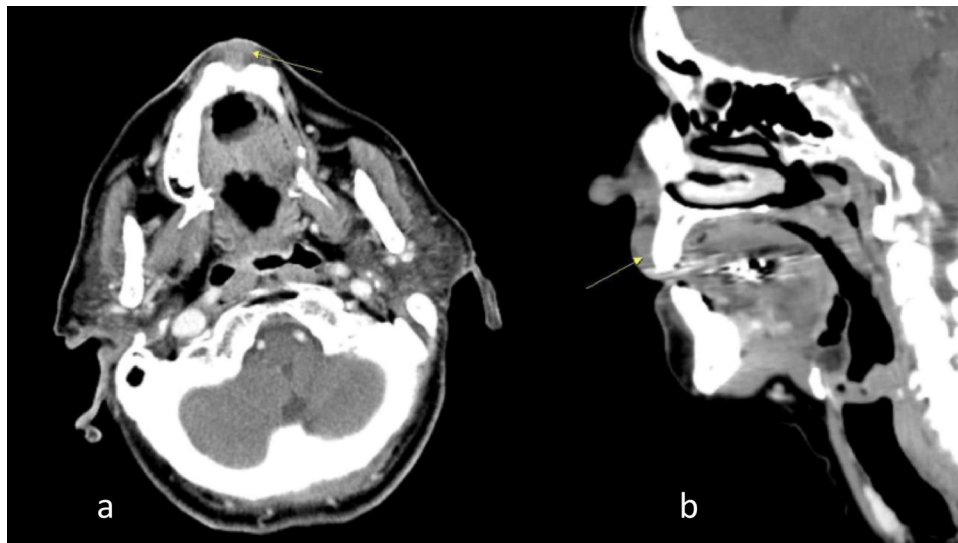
Multi-slice computed tomography axial (a) and sagittal (b) reconstructions. Arrows point to the lesion.
